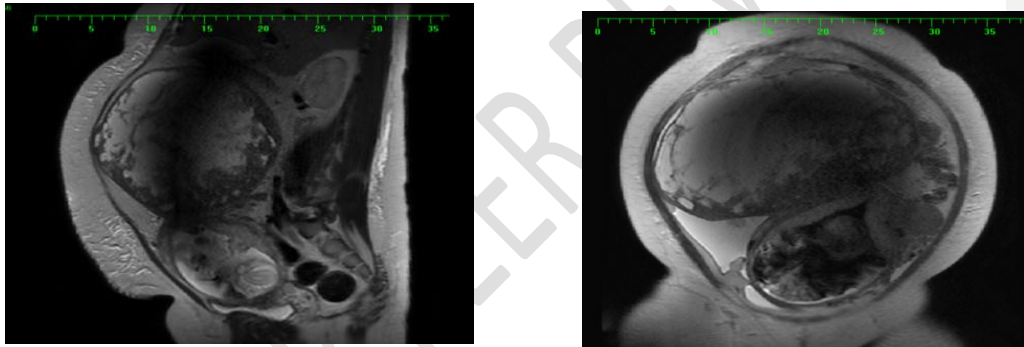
Sagittal T2 weighted MRI of the abdomen and pelvis showing a large well-defined heterogenous subserosal leiomyoma arising from the uterine fundus with predominantly high T2 signals. Gravid uterus with single fetus (partially showed).
